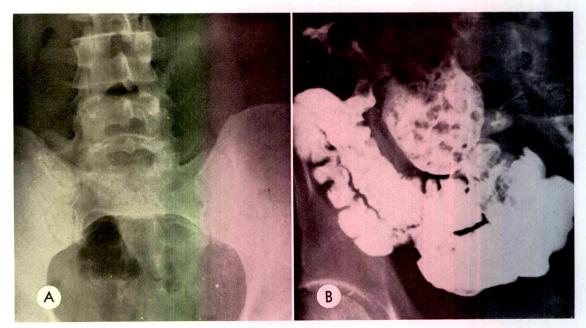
Case II. (A) Erect study of abdomen shows an isolated, gas-containing structure in right lower quadrant within which is an air-fluid level. The absence of gas elsewhere in the abdomen suggests a stagnant or obstructed loop or pocket. (B) Distended blind end of proximal segment of the lateral ileoileal anastomosis filled with barium during a gastrointestinal examination. Filling defects within pouch are due to feces. This pouch is identical in roentgen appearance with the one seen in the previous case (Fig. 2C) except that the narrow neck is not seen. There is also a similarity between these pouches and the one seen in Case VII (Fig. 8).
